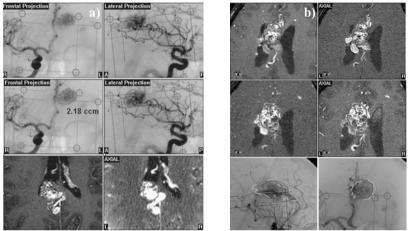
a) Stereotactically performed DSA with a compact AVM nidus (*above left: anterior-posterior projection, above right: lateral projection*), nidus delineated in both projections (*center left and right*) and integrated in an axial slice of MRI (*below left*) and CT (*below right*). b) MRI, TOF-MRA and DSA of an AVM with the defined DSA target volume (*brown line*) and final target volume (*yellow line*), overestimated DSA contour (*above left: MRI, above right: MRA*), underestimated DSA contour (*center left: MRA, center right: MRI*), both overlapping contours (*below left lateral and below right anterior-posterior projection of the DSA*).
